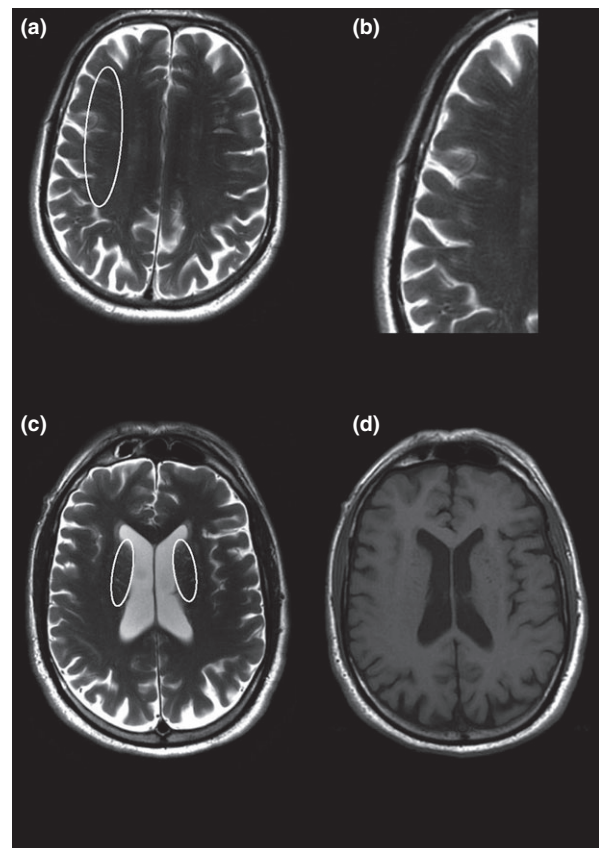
Examples of extensive enlarged perivascular spaces in MRI. (a) Extensive (>10) enlarged perivascular spaces in the centrum semiovale (lines in circle) in T2-weighted MRI; (b) magnification of the region indicated in (a). (c) Extensive enlarged perivascular spaces in the basal ganglia (lines and dots in circles) in T2-weighted MRI; (d) in T1-weighted MRI.
